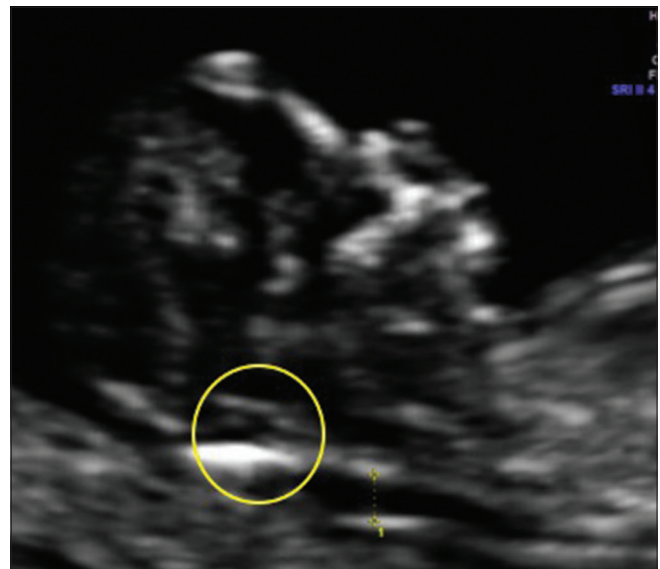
Ultrasound image of mid-sagittal section of fetal head showing normal IT. Thalamus (T), Midbrain (M), Brainstem (B), Medulla Oblongata (MO), Nuchal translucency (NT), and Nasal bone (NB)
